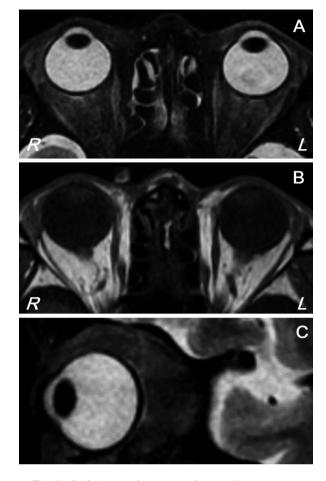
Orbital magnetic resonance images after treatment. (A) An axial short TI inversion recovery (STIR) image (TR: 4,700 ms, TE: 41.98 ms) shows resolution of mild right eyelid swelling and lacrimal gland enlargement. (B) An axial  $T_1$ -weighted image (TR: 540 ms, TE: 12 ms) shows a normal lacrimal gland and orbit. (C) A sagittal STIR image (TR: 4,760 ms, TE: 42.66 ms) reveals improvement of orbital inflammation in the right eye.
